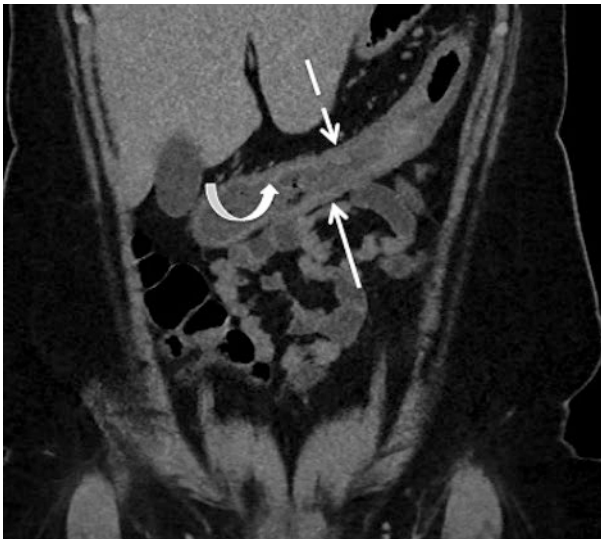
A 43-year-old man presents with abdominal pain, diarrhoea and raised inflammatory markers. Coronal contrast-enhanced CT abdomen/pelvis demonstrates thickening of the wall (solid arrow) and haustra (dashed arrow) of the transverse colon with mucosal high attenuation/hyperenhancement (curved arrow). Findings are in keeping with acute colitis
